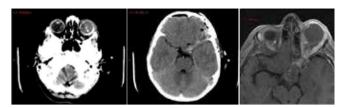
On preoperative non-contrast enhanced cranial CT images; the left eye is hyperdense compared to the right. There is a 36x20 mm mass in the left lateral orbital region, causing inferomedial and anterior deviation of the left eye. Also there are calcifications on posterolateral wall of the eye. No bone invasion is seen.
